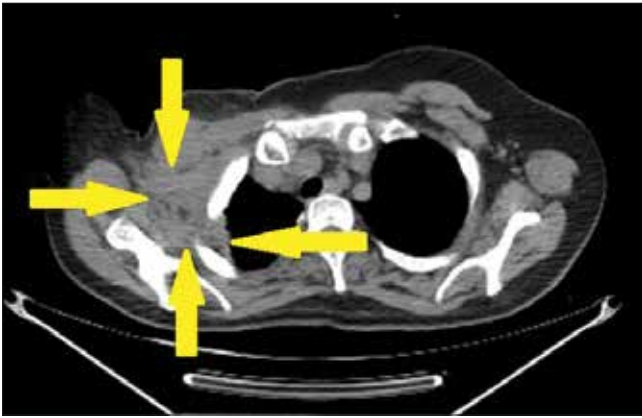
CT scan image visualizing axillary mass invading thoracic wall extending to the parietal pleura (tumor borders outlined by yellow arrows)
